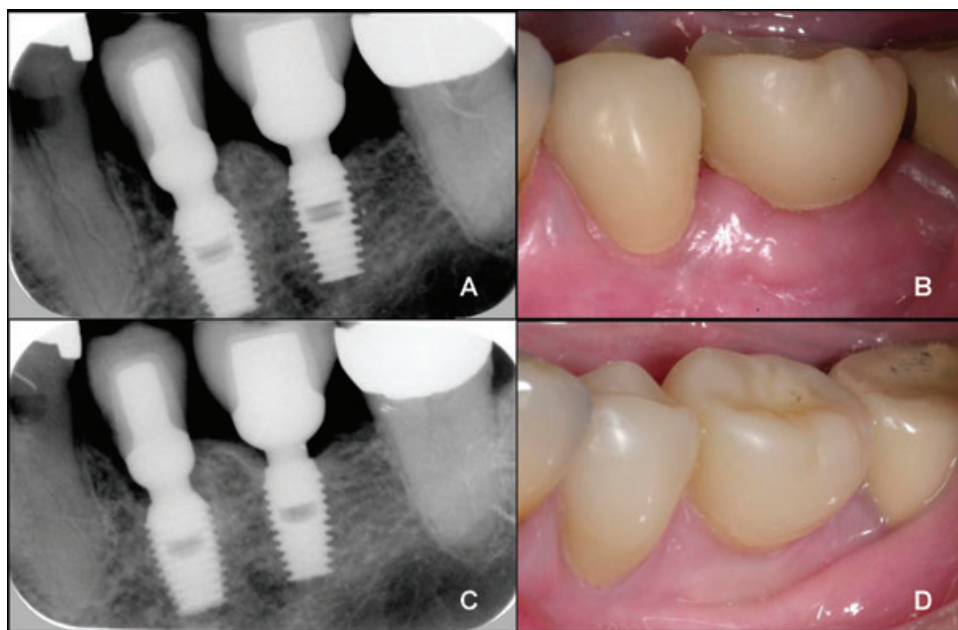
Periapical radiographs and clinical pictures of IACs restoring the same mandibular left bicuspid and first molar area presented in Figure 2. At crown insertion, June 2002 (A, B) and at a recall appointment, February 2004 (C, D).
